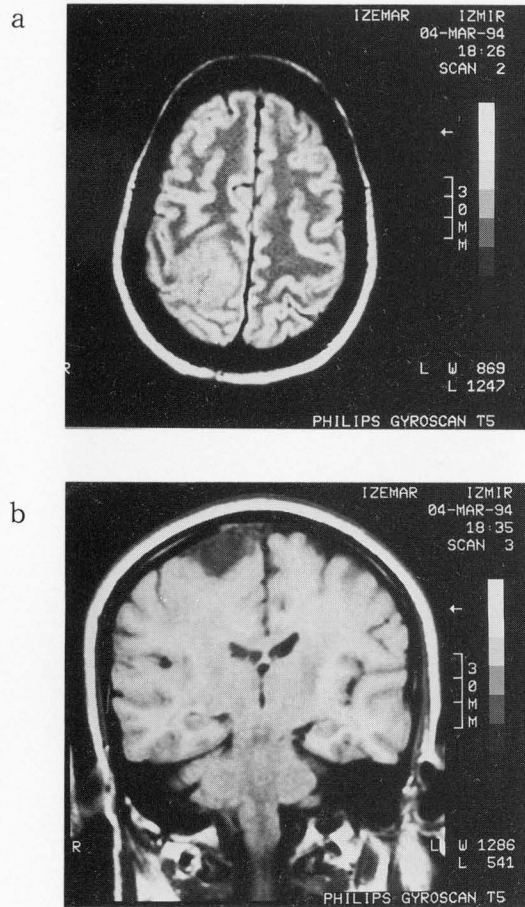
Proton density (a) and T2-weighted (b) MRI showing the tumour.
